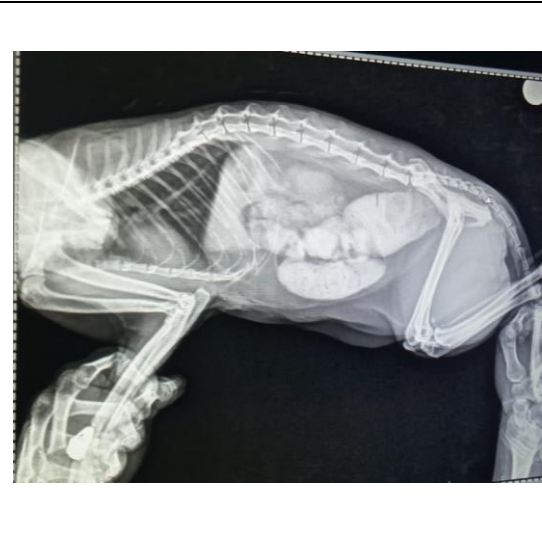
Radiograph revealed radiopaque large size faecoliths.
